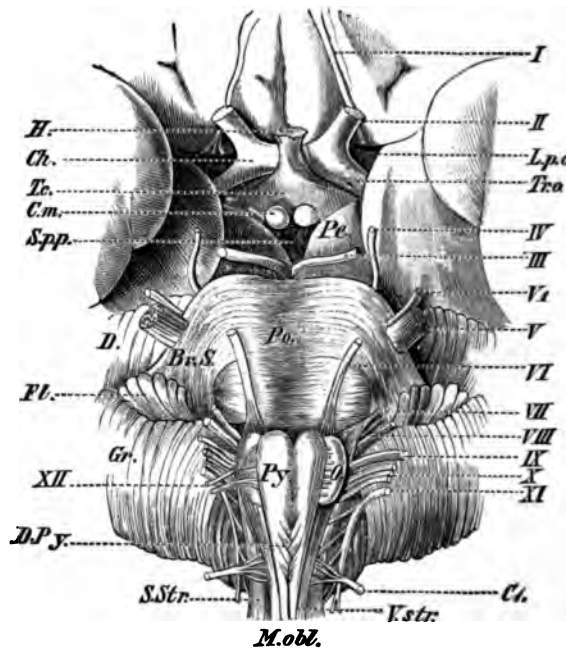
BASAL ASPECT OF THE CEREBRAL AXIS.
